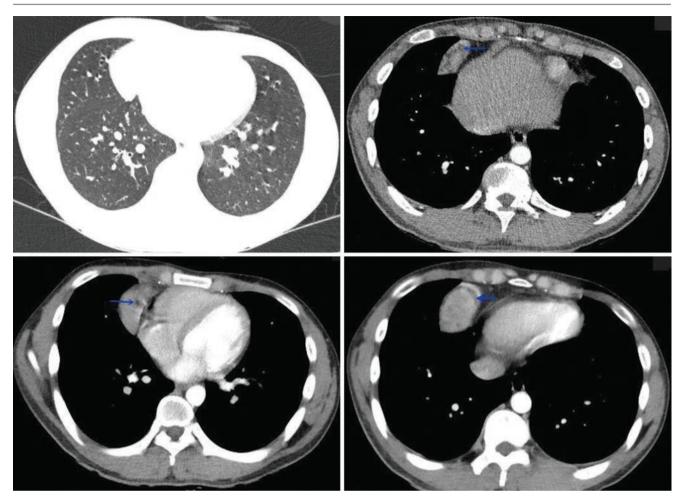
Chest CT images of an 18-year-old man's physical examination revealed mediastinal mass
